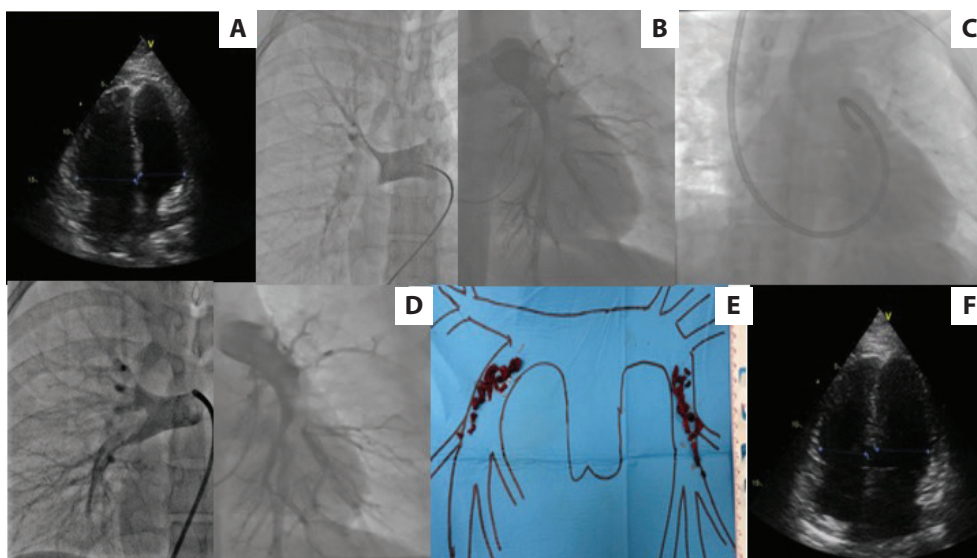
A. Echocardiography (apical four-chamber view) showing enlargement of the right ventricle (RV) before the procedure. B. Selective angiography of the right (RPA) and left pulmonary artery (LPA) before the procedure. C. The catheter-directed mechanical aspiration thrombectomy procedure with the Lightning 12 system in the LPA. D. Selective angiography of the RPA and LPA after the procedure. E. An image of the removed clots. F. Echocardiography (apical four-chamber view) showing normalization of the RV dimension after the procedure
